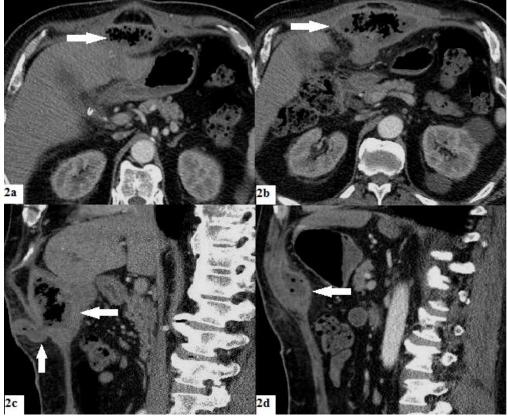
Contrast-enhanced abdominal CT scan showing a falciform ligament abscess with arrows. Discussion
